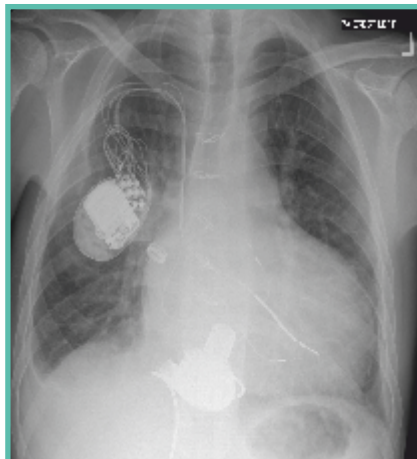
Chest radiograph showing the implanted Heartware HVAD posteriorly positioned in the systemic ventricle.
